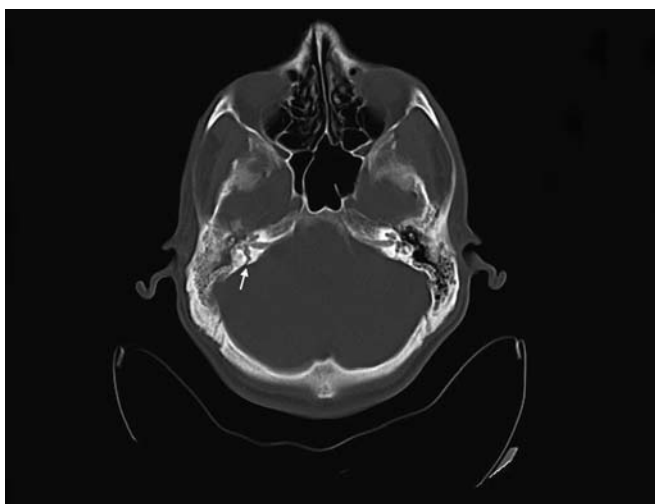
Thirty-year-old male with transverse temporal bone fracture (Number 2 patient in the table). This temporal bone HRCT shows right side transverse temporal bone fracture includes labyrinth (arrow).
